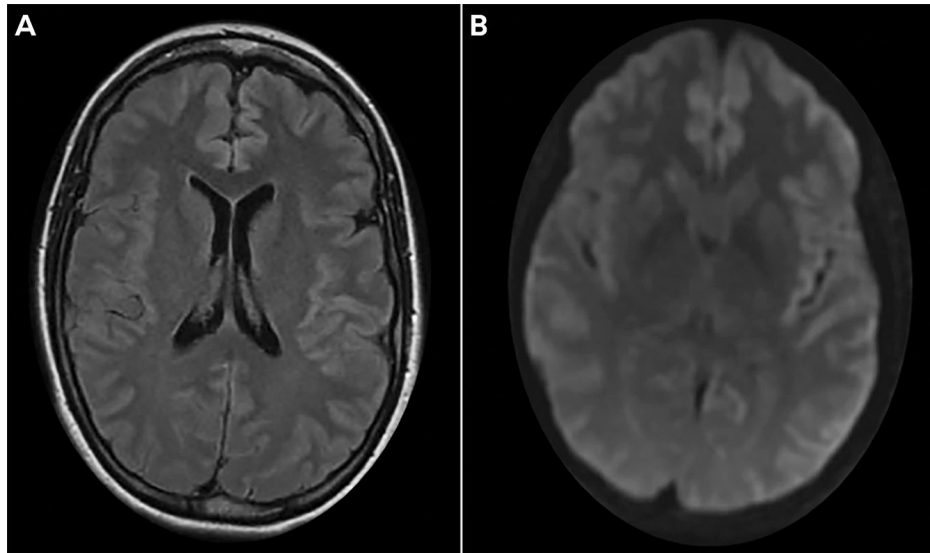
Imaging of the patient in CASE 13-5. Axial fluid-attenuated inversion recovery (FLAIR) (*A*) and diffusion-weighted image (*B*) show increased signal within the cortical ribbon, most prominent in left frontal, parietal, and temporal areas.
